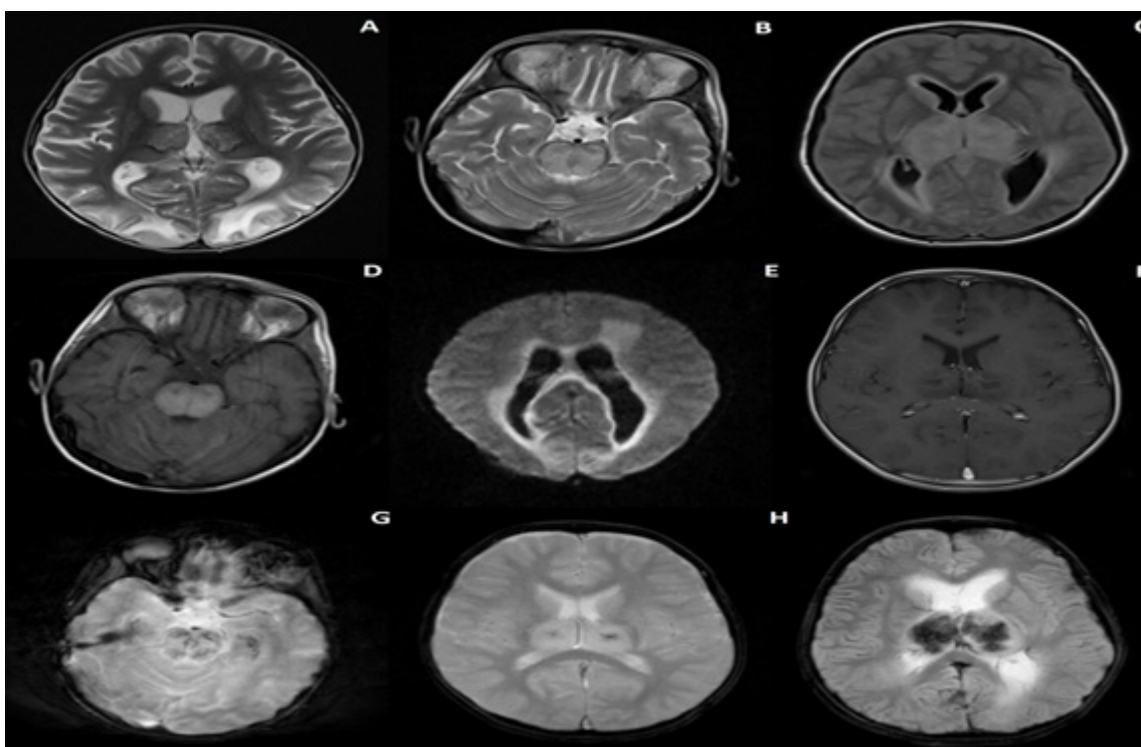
Showing some of the MRI findings
